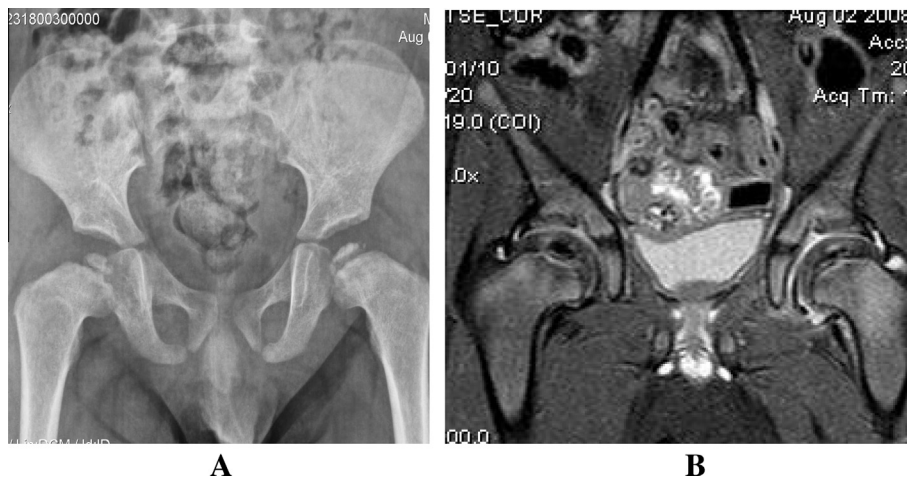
Bilateral femoral head AVN. (A) Plain X ray AP pelvis showing bilateral femoral head collapse and sclerosis. (B) Coronal MRI STIR showing femoral head double line sign, collapse and secondary osteoarthritis of hip joints.
